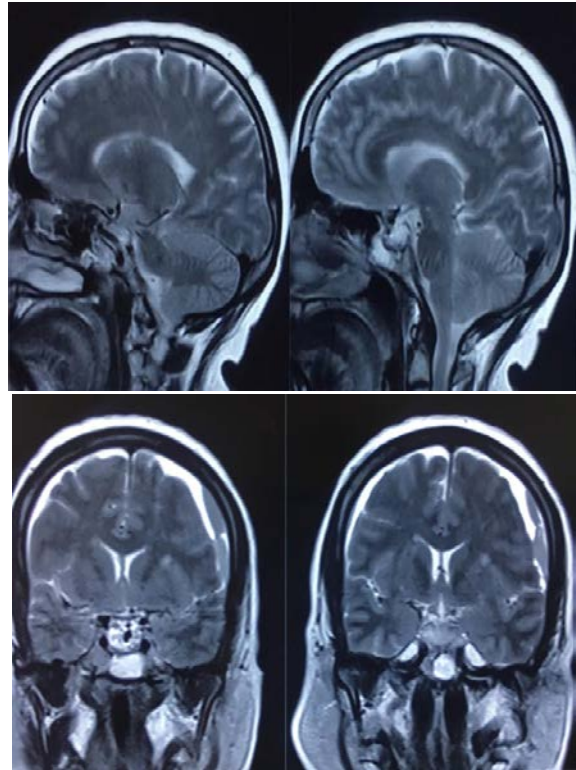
Patient's MRI indicating air accumulation in sella turcica and bilateral subdural effusion.
